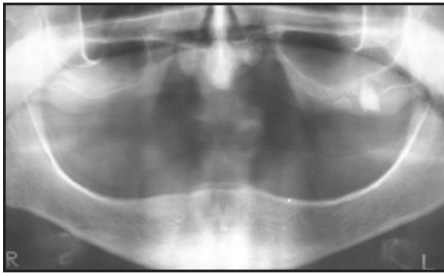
The preoperative panoramic radiograph of patient no. 1
